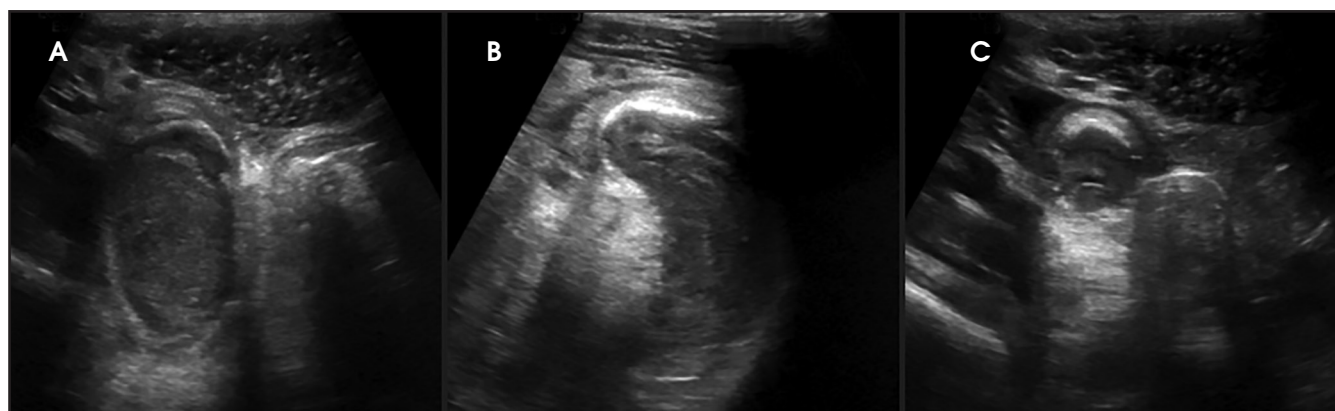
Abdominal ultrasound. (A-C) A heterogenic and concentric layered lesion is seen in the abdominal RLQ. The lesion shows peripheral hyperechogenicity and slight acoustic shadow. Hyperechogenicity of the adjacent fat and free fluid are also seen.
